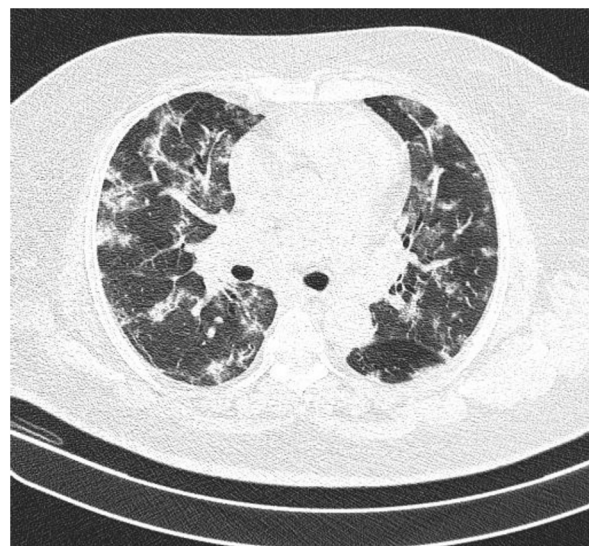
Axial CT scan of the thorax, lung window showing diffuse ground glass opacities in both lung fields.
